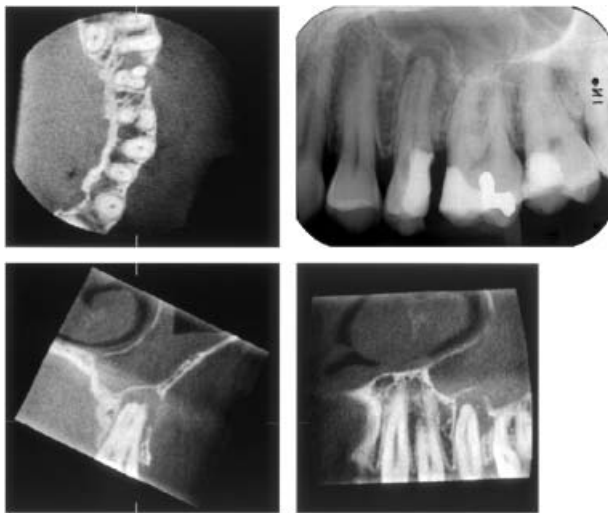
In this patient, the upper left second premolar showed a large periapical lesion with a breakdown of part of its buccal border and of that expanding into the maxillary sinus in which there is an extensive soft-tissue reaction. Note also, in the axial view, that the tooth had no less than three roots. In the periapical radiograph, little of all this information was obtained.
